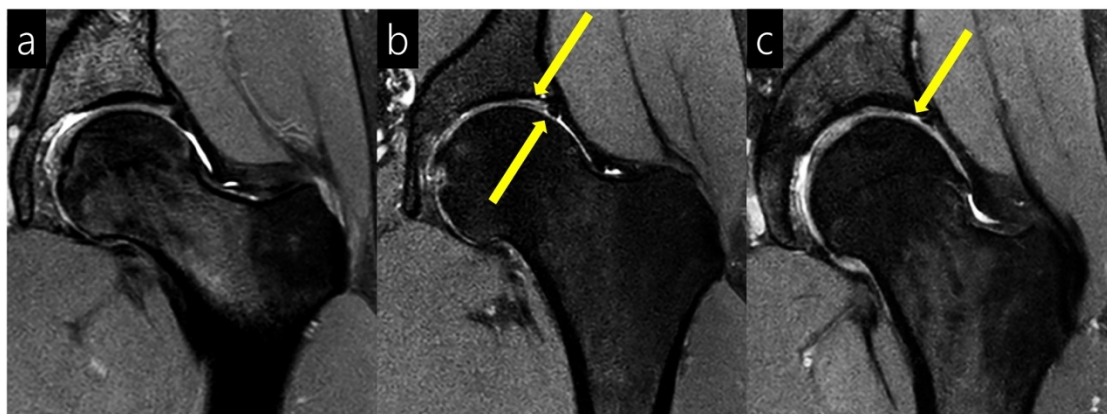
Cartilage conditions on unenhanced MRI.
